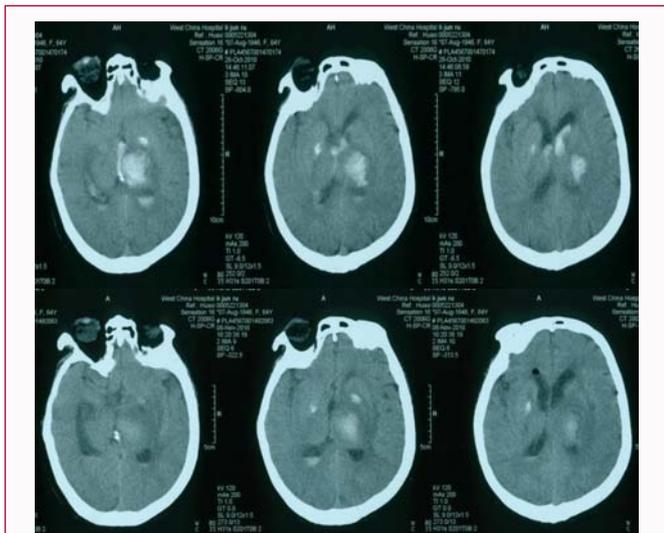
Preoperative CT scan (Above) of Case V (46/F) indicating left ICH with ventricle extension on admission and managed by burr hole drainage. Post-operative CT scan (Below) of Case II (46/F) showing hematoma almost disappeared.
